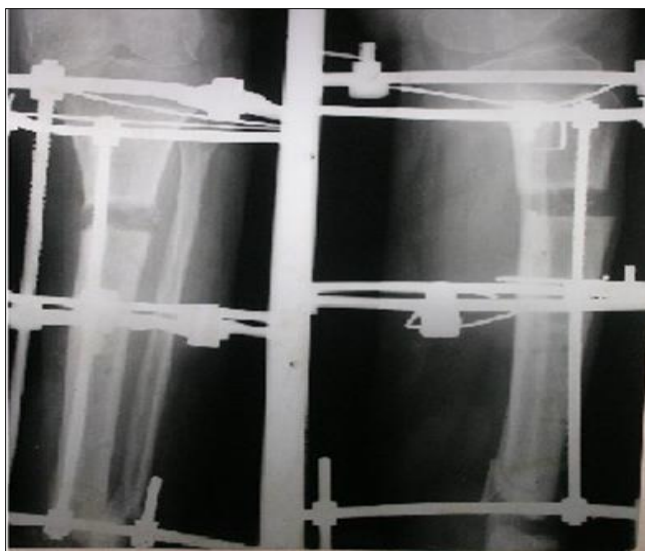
X-ray showing three weeks of gap Post transport.
